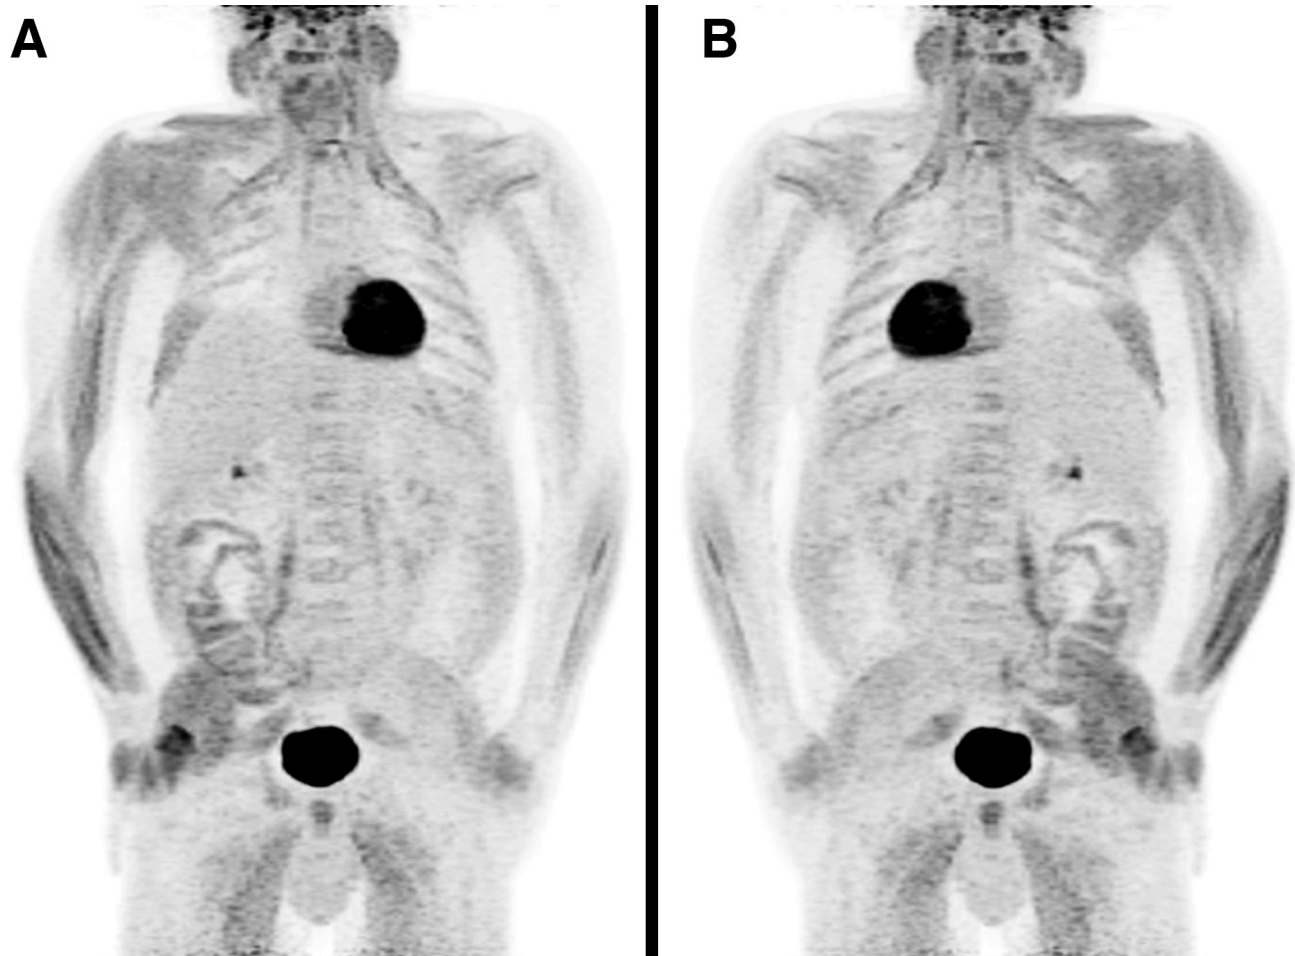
A 49-year-old male patient had ^{18}F -fluoro-2-deoxy-D-glucose (^{18}F -FDG) positron emission tomography/computed tomography (PET/CT) (Biograph-mCT, Siemens, Germany) to stage a rectal squamous cell carcinoma. He was injected with 352 MBq of ^{18}F -FDG and his blood glucose was 6.8 mmol/L just prior to injection. During the 60-minute uptake phase prior to imaging, the nurse observed the patient: he was sitting and leaning on one side, appeared intoxicated and his breath smelled of alcohol. He was constantly moving in his seat. Two beer cans were found in the waste disposal next to his chair just prior to imaging. On questioning, he denied drinking alcohol and only admitted to eating a cookie at approximately 30 minutes after ^{18}F -FDG injection. PET/CT maximum intensity projection images with (A) anterior and (B) posterior views revealed diffuse intense unilateral muscle ^{18}F -FDG uptake artifacts involving the right shoulder, arm, hand, right chest wall and right gluteus muscles.
